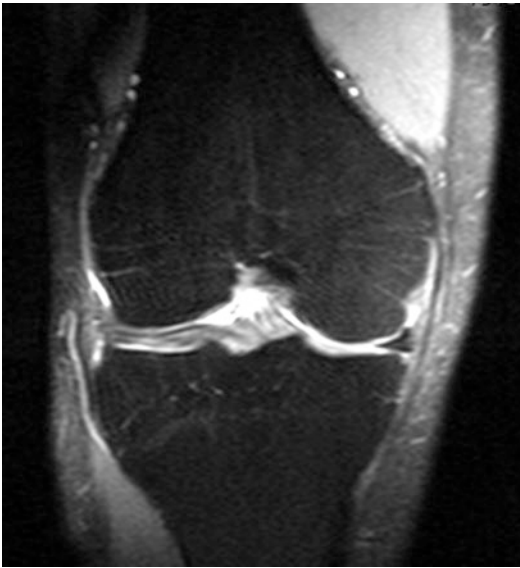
Magnetic resonance image of a central tear of a discoid lateral meniscus
